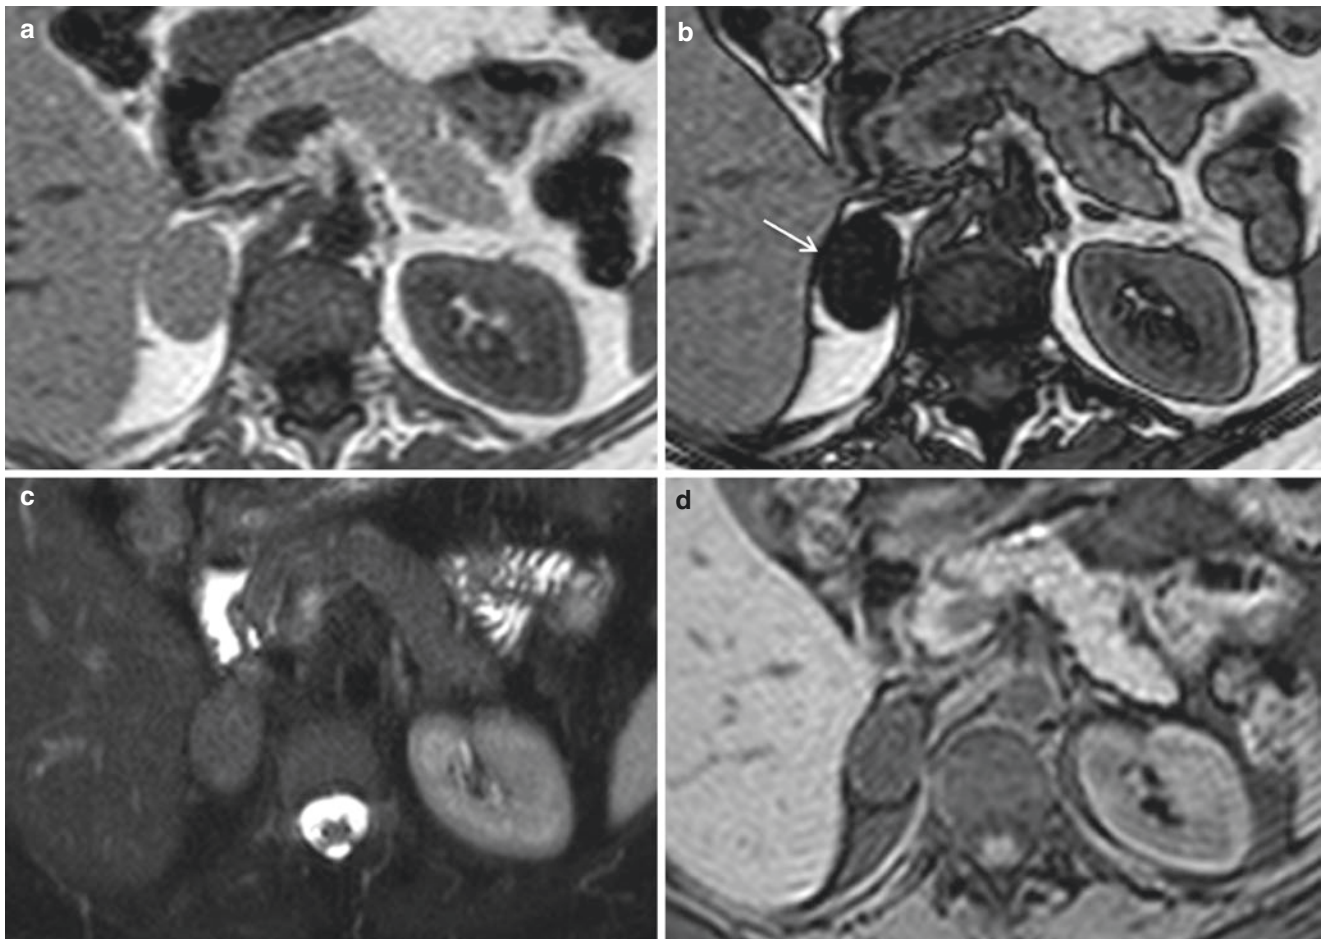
Right adrenal adenoma. Axial in-phase (a) and out-of-phase T1-weighted MR images and axial fat-suppressed T2-weighted (c) and T1-weighted (d) images with accentuated and homogeneous loss of signal intensity on out-of-phase image (b, white arrow)
